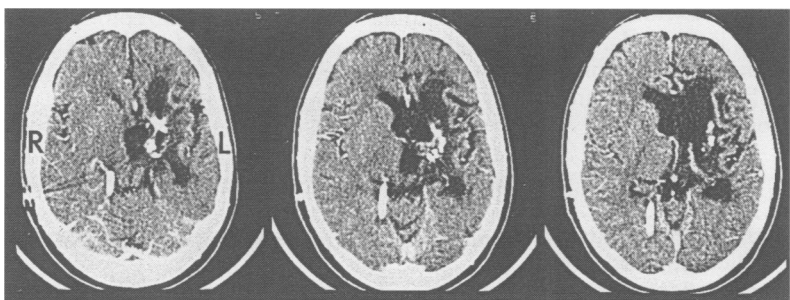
Axial enhanced CT scans of patient 19, 14 years after interstitial radiotherapy with ^{125}I . The patient had presented with dystonia of the right arm due to a grade I astrocytoma of the left thalamus and basal ganglia. She also had transient right hemichorea. The CT scans demonstrate the late effects of radionecrosis with metallic artefacts of the ^{125}I wires, calcifications and gliosis. There is no evidence of residual tumour.
